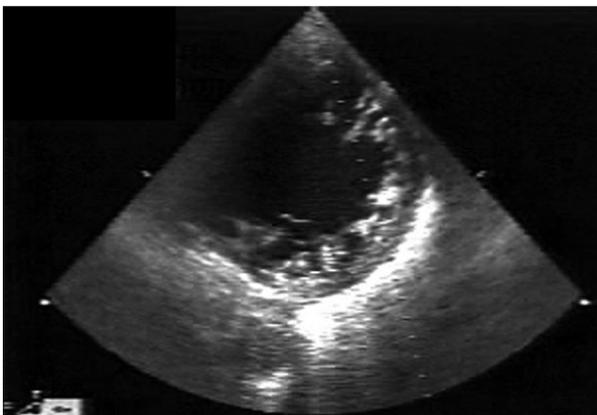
Parasternal short axis view showing left ventricular walls structure with a compact epicardial layer and an endocardial layer consisting of a prominent trabecular meshwork and deep intertrabecular spaces.
